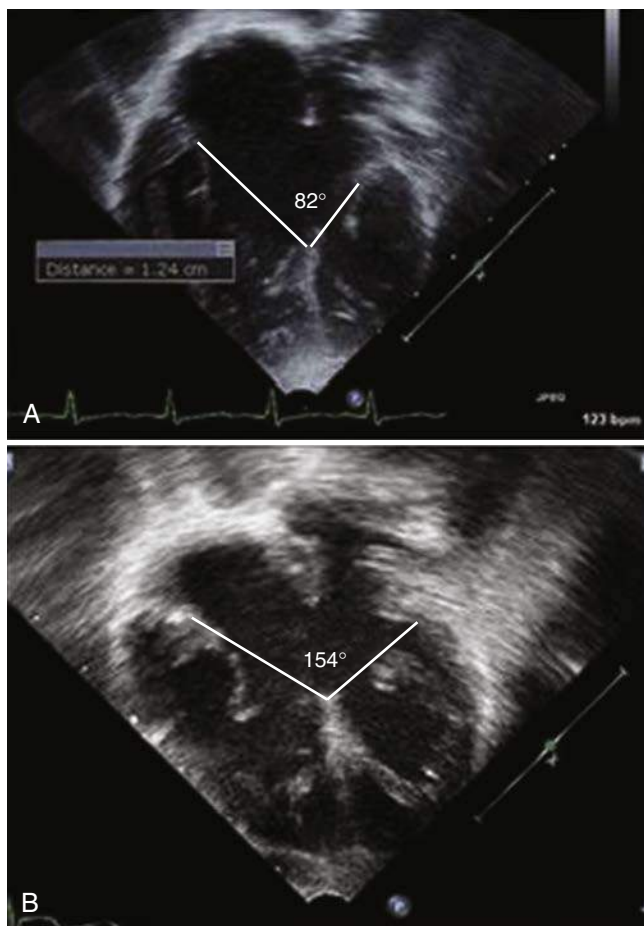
Right ventricle/left ventricle (RV/LV) inflow angle. In the apical four-chamber view, the angle of the right-to-left ventricular inflow is measured from the crest of the ventricular septum to each atrioventricular valve hinge point. The angle is derived at the crest of the ventricular septum. A, An example of a patient with right-dominant, unbalanced atrioventricular septal defect (AVSD) with an RV/LV angle of 82 degrees. B, An example of a patient with balanced AVSD with an angle of 154 degrees. (From Cohen MS, Jegatheeswaran A, Baffa JM, et al. Echocardiographic features defining right dominant unbalanced atrioventricular septal defect: a multi-institutional Congenital Heart Surgeons' Society study. *Circ Cardiovasc Imaging*. 2013;6: 508-513.)
